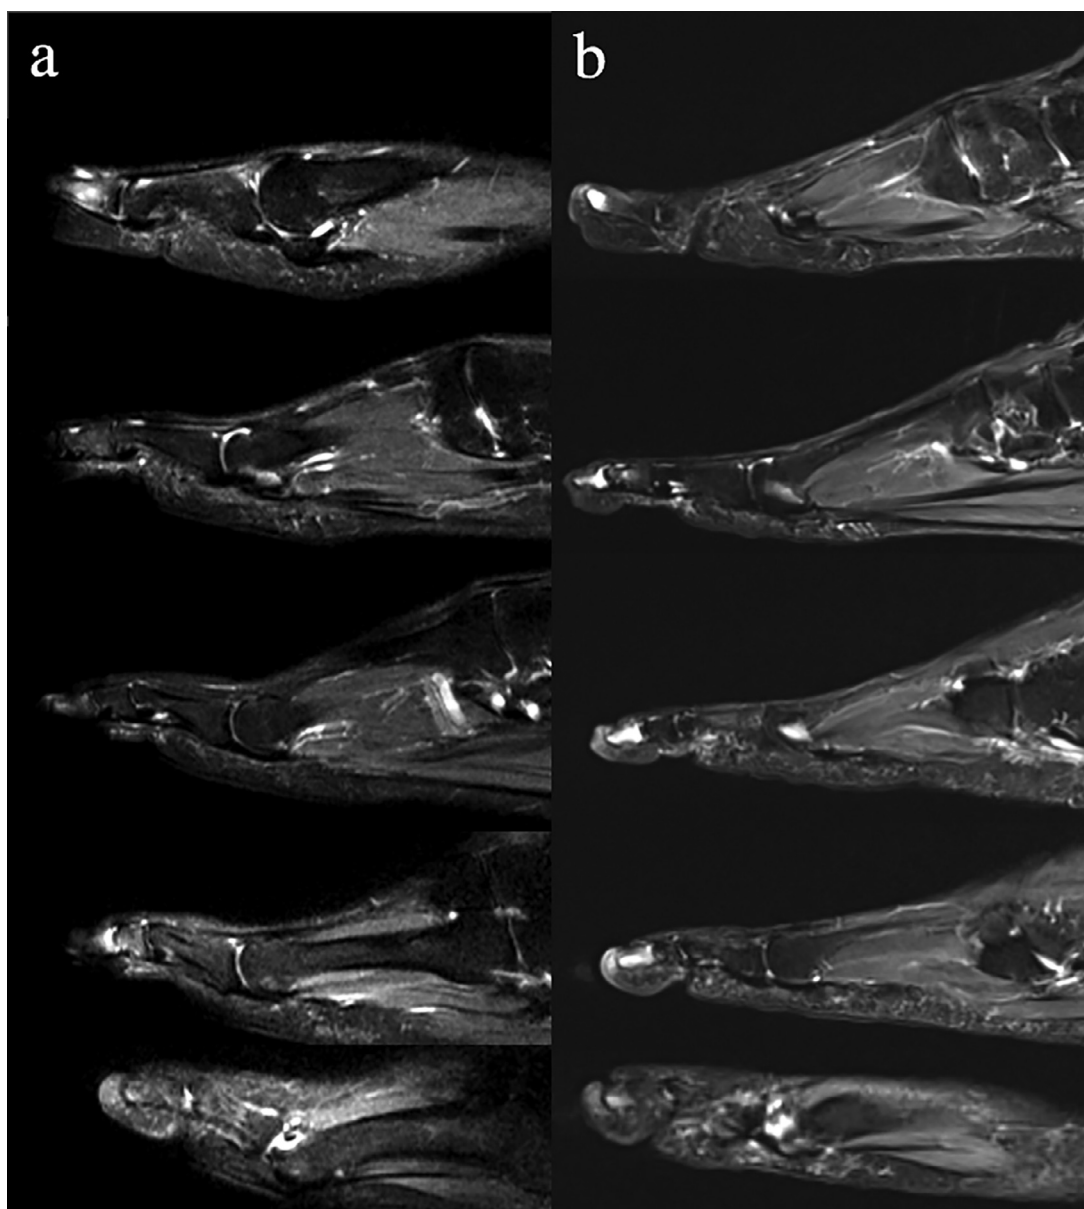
Initial (a) and 2.5-year follow-up (b) MRI STIR images of the right foot demonstrate progressive distal-to-proximal hyperintense signal abnormalities in the distal phalanges. Toes are arranged from first (top) to fifth (bottom).
